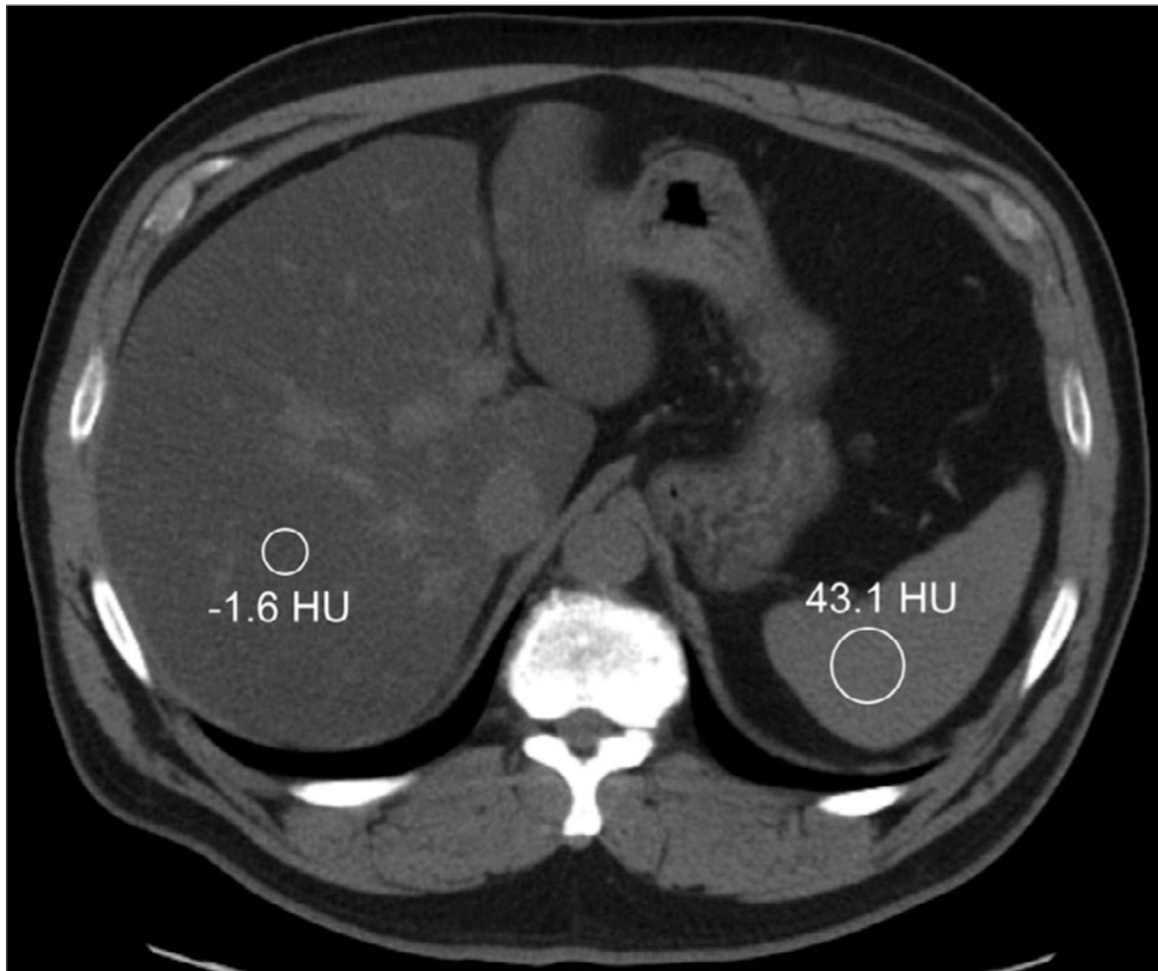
Single-energy computed tomography methodology for diagnosis of hepatic steatosis utilizes regions of interest in the liver and spleen, shown here in a 61-yr-old male seen for restaging of a pancreatic neuroendocrine tumor. The liver attenuation in this case is both below 40 HU and more than 10 HU lower than that of the spleen, indicating the presence of diffuse fat within the liver tissue.
